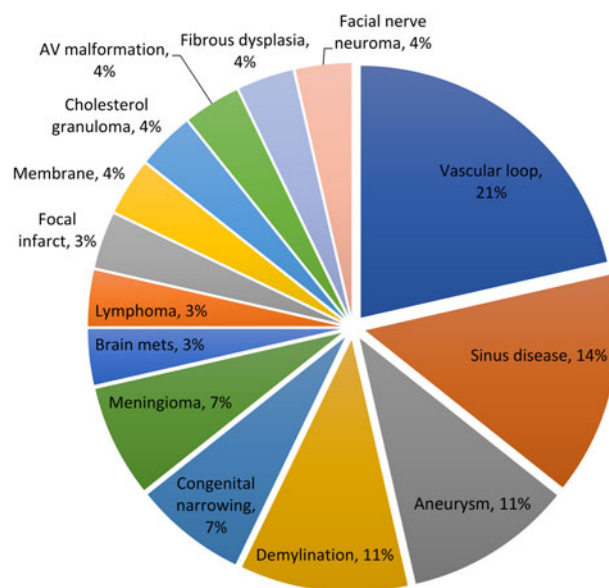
Other incidental findings in addition to mastoiditis seen on magnetic resonance imaging scans. AV = arteriovenous; mets = metastasis
